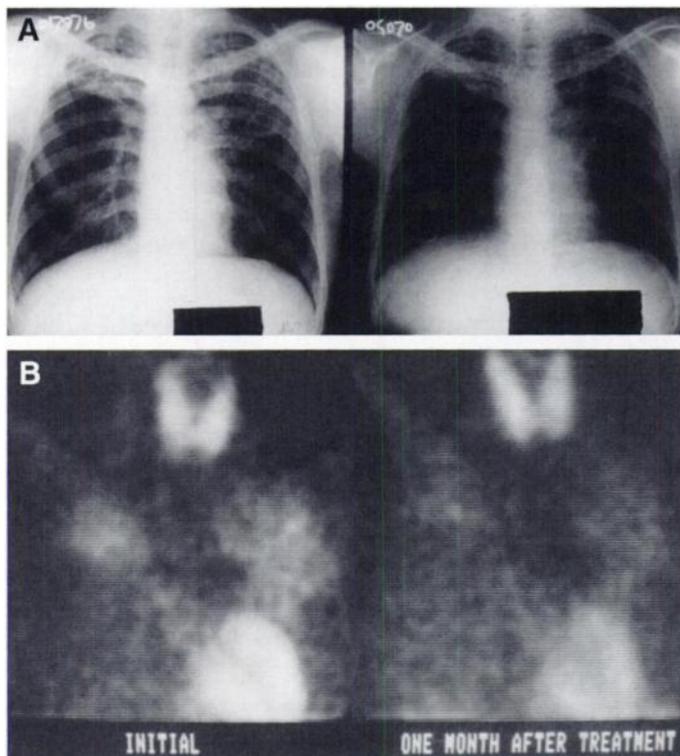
Patient 8, a 26-yr-old man with active localized PTB in both lungs. (A) Postero-anterior chest roentgenogram on the left side demonstrates focal infiltration with some cavitation in both upper lung fields being more prominent on the left side. Despite exposure differences, partial regression of the lesions is seen on the right radiograph obtained 1 mo after chemotherapy. (B) Abnormal focal accumulations of ^{99m}Tc-MIBI on 1-hr scan in both upper lungs and partial diminution after chemotherapy can be easily seen in the corresponding scintigraphs.
